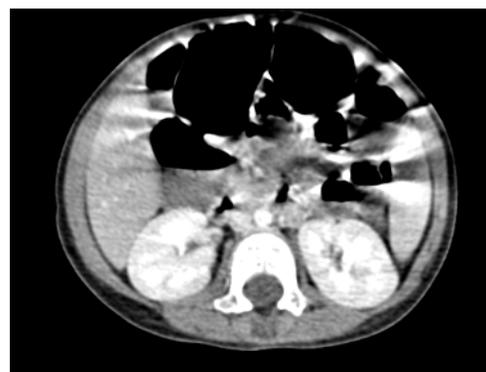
CT scan abdomen of case. 2 at diagnosis
